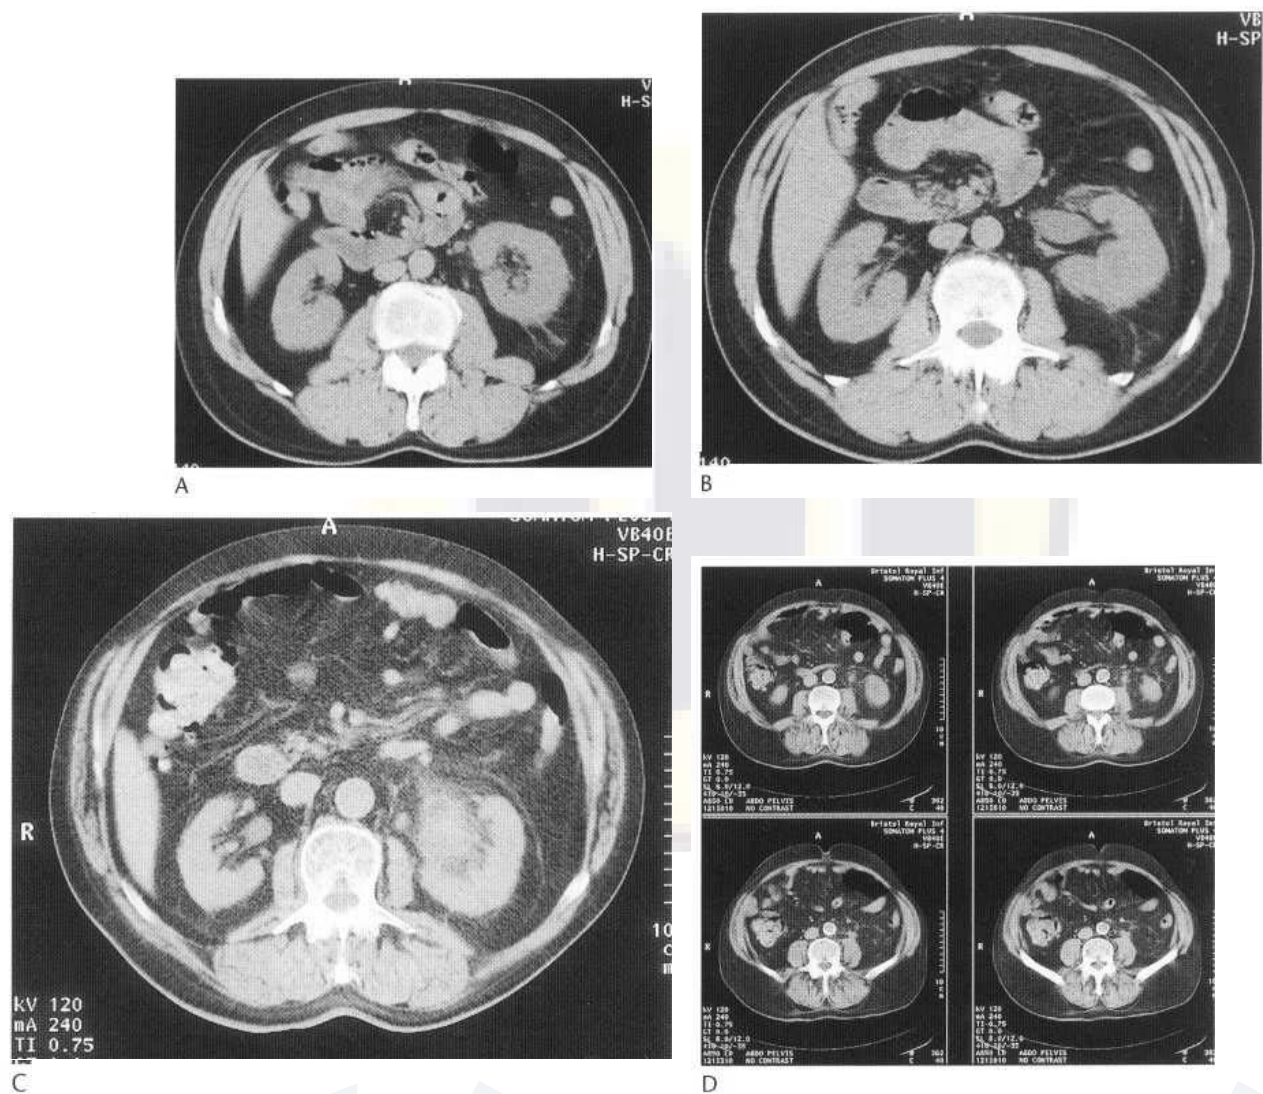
CT showing modest perinephric stranding characteristic of significant obstruction from a ureteric calculus (A). In addition to these changes this second case shows a small fluid collection adjacent to the anterior lip of the renal hilum indicating a forniceal rupture (B). The acute hydronephrosis is generally mild, as demonstrated in this third example (C), but the asymmetry between the sides is useful (although this patient demonstrates a slightly full extrarenal pelvis on the asymptomatic side). There is mild perinephric stranding on the symptomatic (left) side but considerable ill-definition around the renal pelvis, suggesting some extravasation into the renal sinus. This can be seen to track down along the dilated ureter, giving it a shaggy appearance (D).
